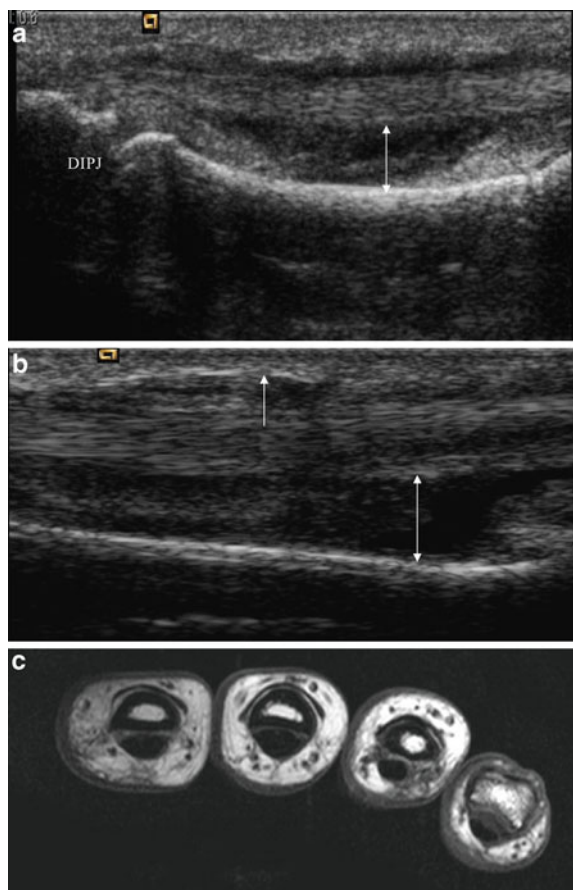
a, b Both images taken in the same patient show increased tendophalangeal distance (*double arrow heads*) over the middle and proximal phalanges respectively, indicating rupture of the A2 and A4 pulleys. *Arrow* in b shows the ruptured A2 pulley. c Axial MR image shows increased tendophalangeal distance (*double arrow heads*) due to chronic rupture of the A2 pulley
